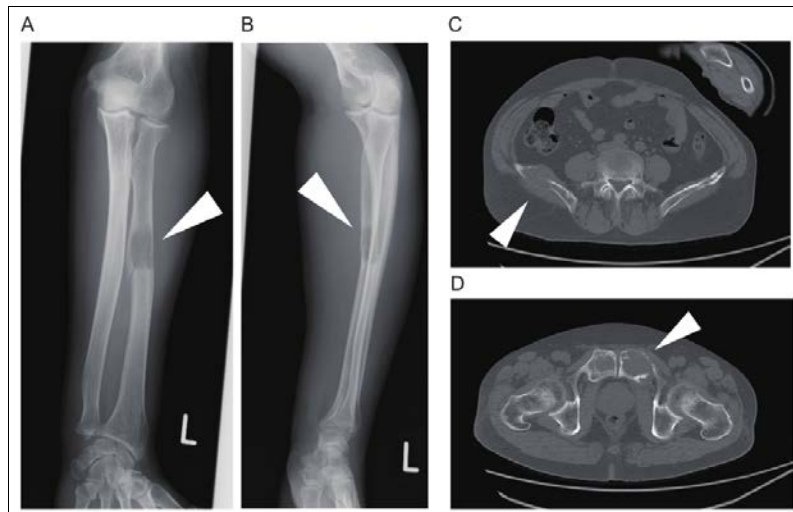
The left radial pathological fracture and multiple osteolytic lesions in the right ilium and the left pubis Plain X-ray AP view (A) and lateral view (B) showing osteolytic lesion and the fracture line without marginal sclerosis in the left radius. CT depicted osteolytic lesions in the right ilium (C) and left pubis (D). Arrowheads indicate osteolytic lesions.
